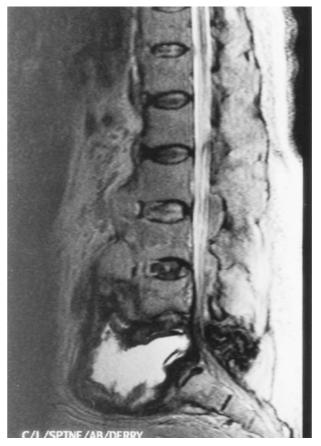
MRI of Lumbar spine, sagittal T2 weighted image. There is collapse at L5 with replacement of the L4–5 level with extensive high signal tissue anteriorly and changes in the posterior elements. Appearances are of pseudoarthrosis with surrounding inflammatory changes at L4–5 level. There is associated canal stenosis adjacent to the L4–5 level and ankylosis at some of the other levels of lumbar spine
